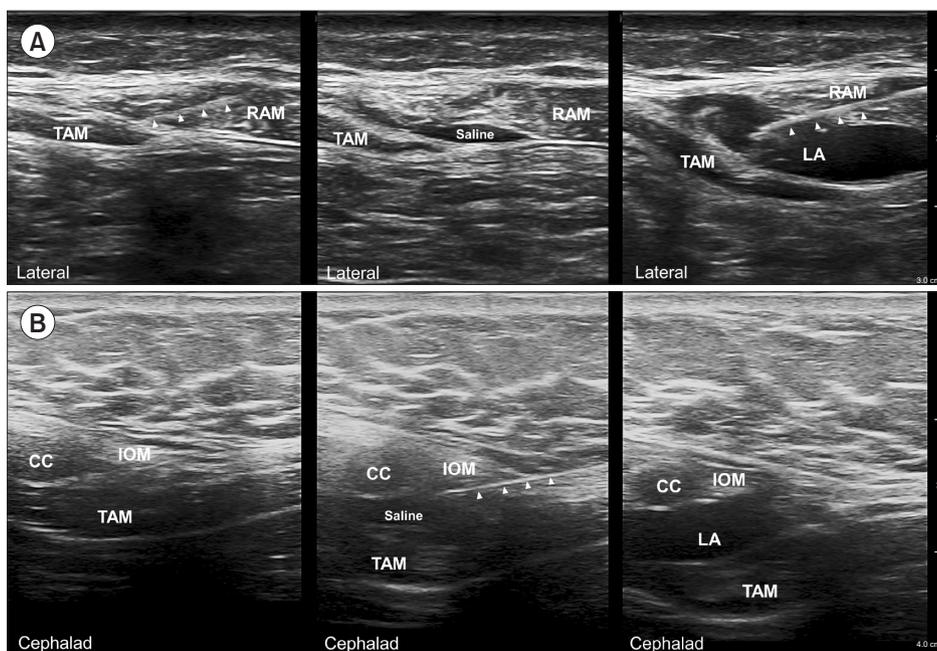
Ultrasound images of subcostal transversus abdominis plane block (A) and modified thoracoabdominal nerve block through perichondral approach (B). The arrow represents the needle. CC: costal cartilage, LA: local anesthetics, RAM: rectus abdominalis muscle, TAM: transversus abdominis muscle, IOM: internal oblique muscle.
